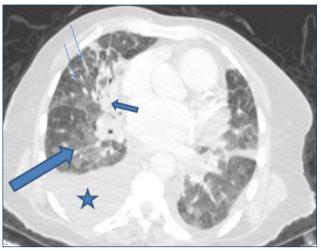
A 76-year-old female patient has wheezing for the past 15 days and severe abdominal pain for one week. There are bilateral pleural effusion and cardiomegaly (blue stars). Bilaterally moderate interlobular septal thickening is observed (thin blue arrows). There is a focal consolidation in the right middle lobe (small thick blue arrow). Perihilar ground-glass opacity are present (long bold blue arrow). Chest computed tomography findings were classified as atypical findings for COVID-19. Pulmonary congestion findings in chest computed tomography suppress typical radiological findings for COVID-19.
